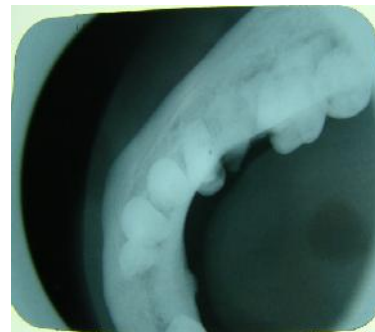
Occlusal radiograph: reveals bone loss in region of 36-37
